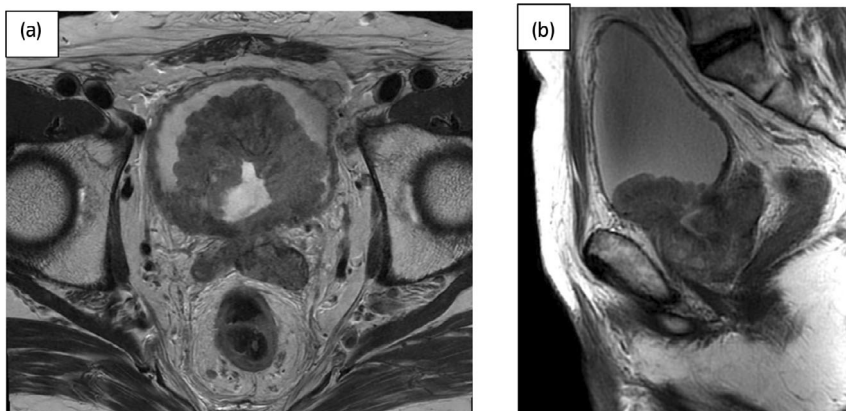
Magnetic resonance imaging (T2-weighted image) (a: axial, b: sagittal). Magnetic resonance imaging reveals a tumor centered on the anterior bladder and extending to the bladder neck.
